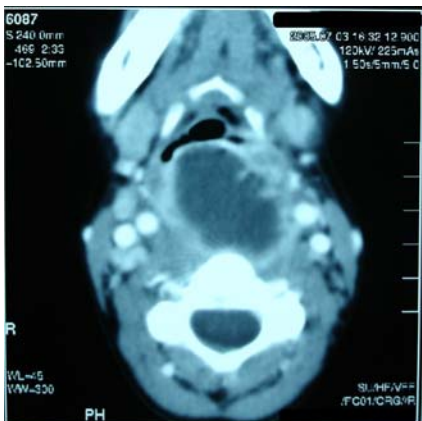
Contrast enhanced CT scan demonstrating a ring enhancement of retropharyngeal abscess.
